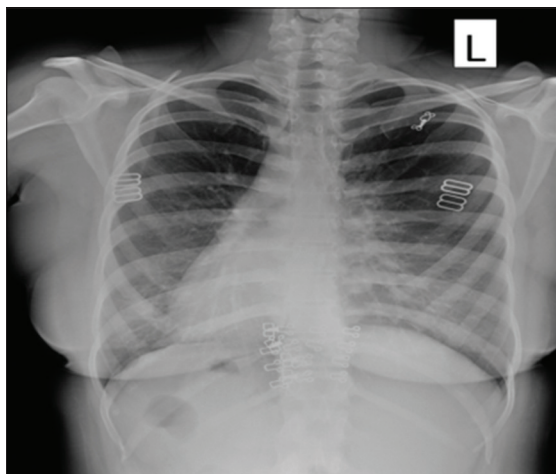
Chest X-ray posteroanterior view shows dextrocardia and fine reticular and fibrocavitary marking in the left perihilar region. The right-sided aortic arch is seen. Stomach bubble is noted on the right side below diaphragm, the left dome of diaphragm is higher as compared to right
